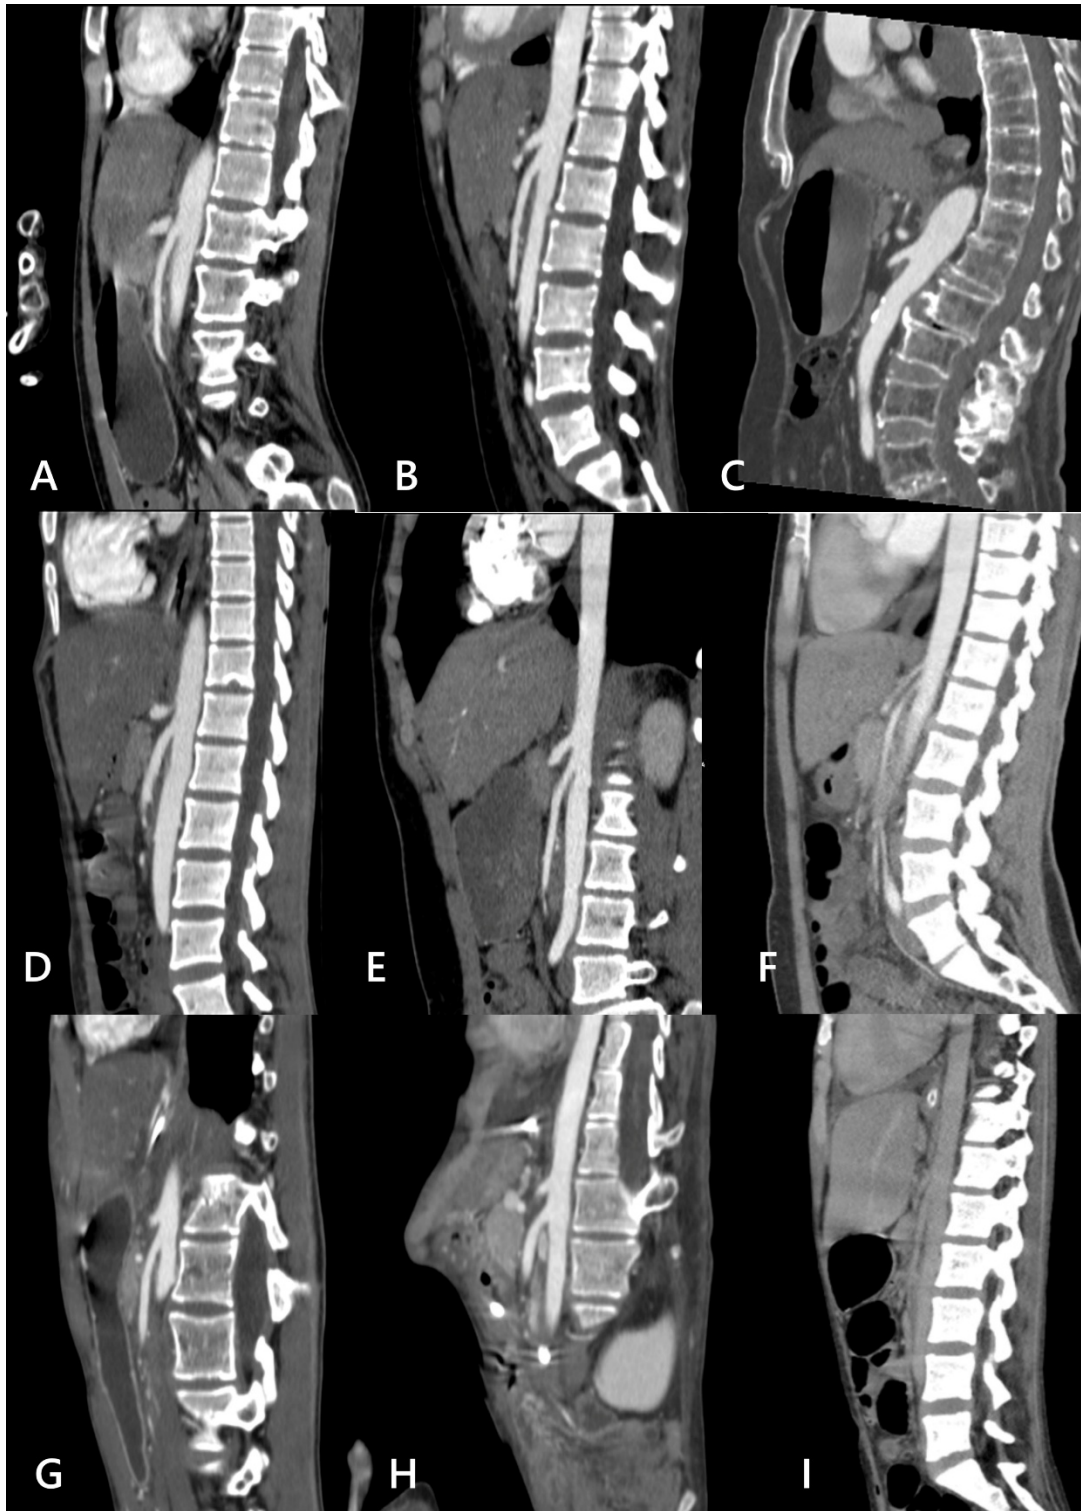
Sagittal Plane of Abdominal Computed Tomography (CT) in the Superior Mesenteric Artery Syndrome (SMAS).
